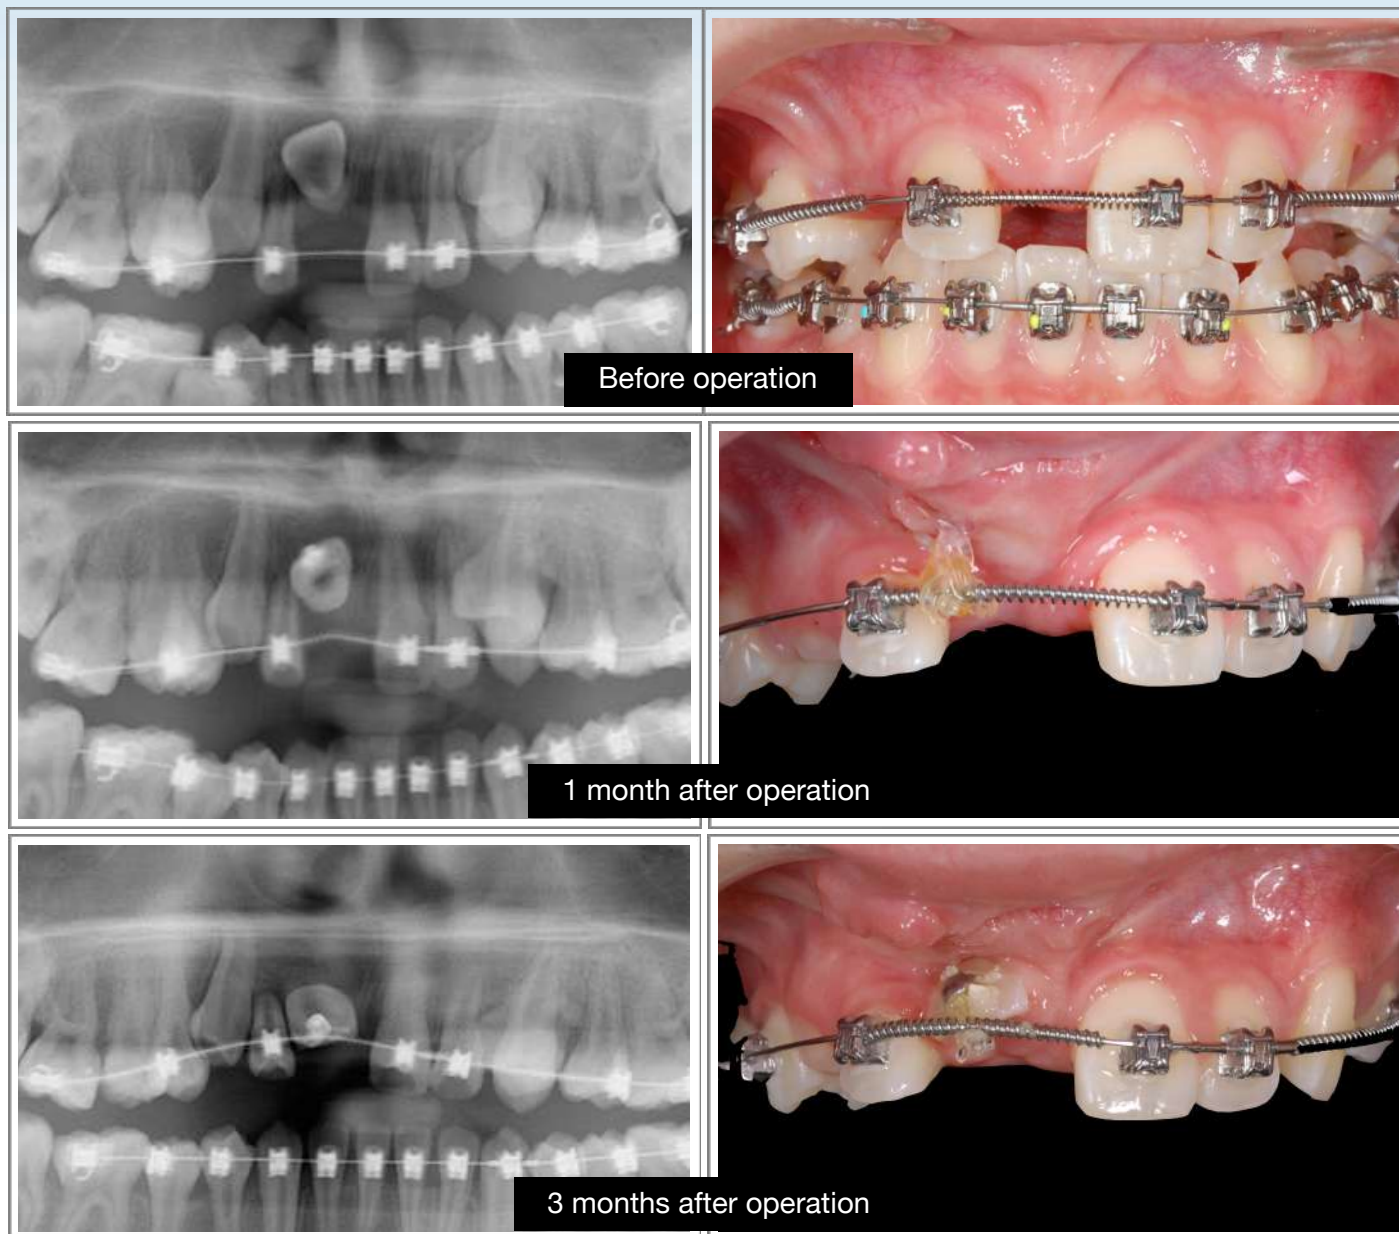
A series of panoramic radiographs are matched to intraoral frontal radiographs at three time intervals: Before operation (upper), 1 month after operation (middle), and 3 months after operation (lower).
